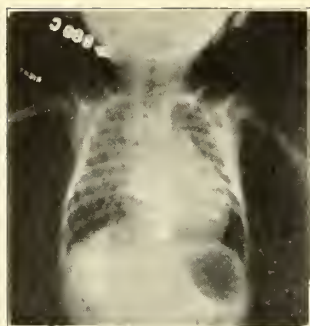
Roentgen ray of chest in Case 4. Enlarged thymic shadow extending down over the heart. Heart markedly enlarged, filling one-half the chest.
